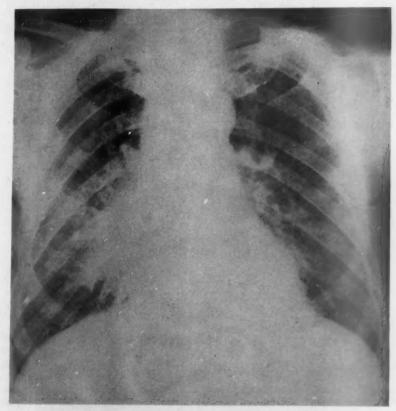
July 17, 1956. Chest x-ray shows diffuse linear infiltrations permeating both lungs. (Later chest x-rays showed increase infiltrations, also cardiac enlargement.)
